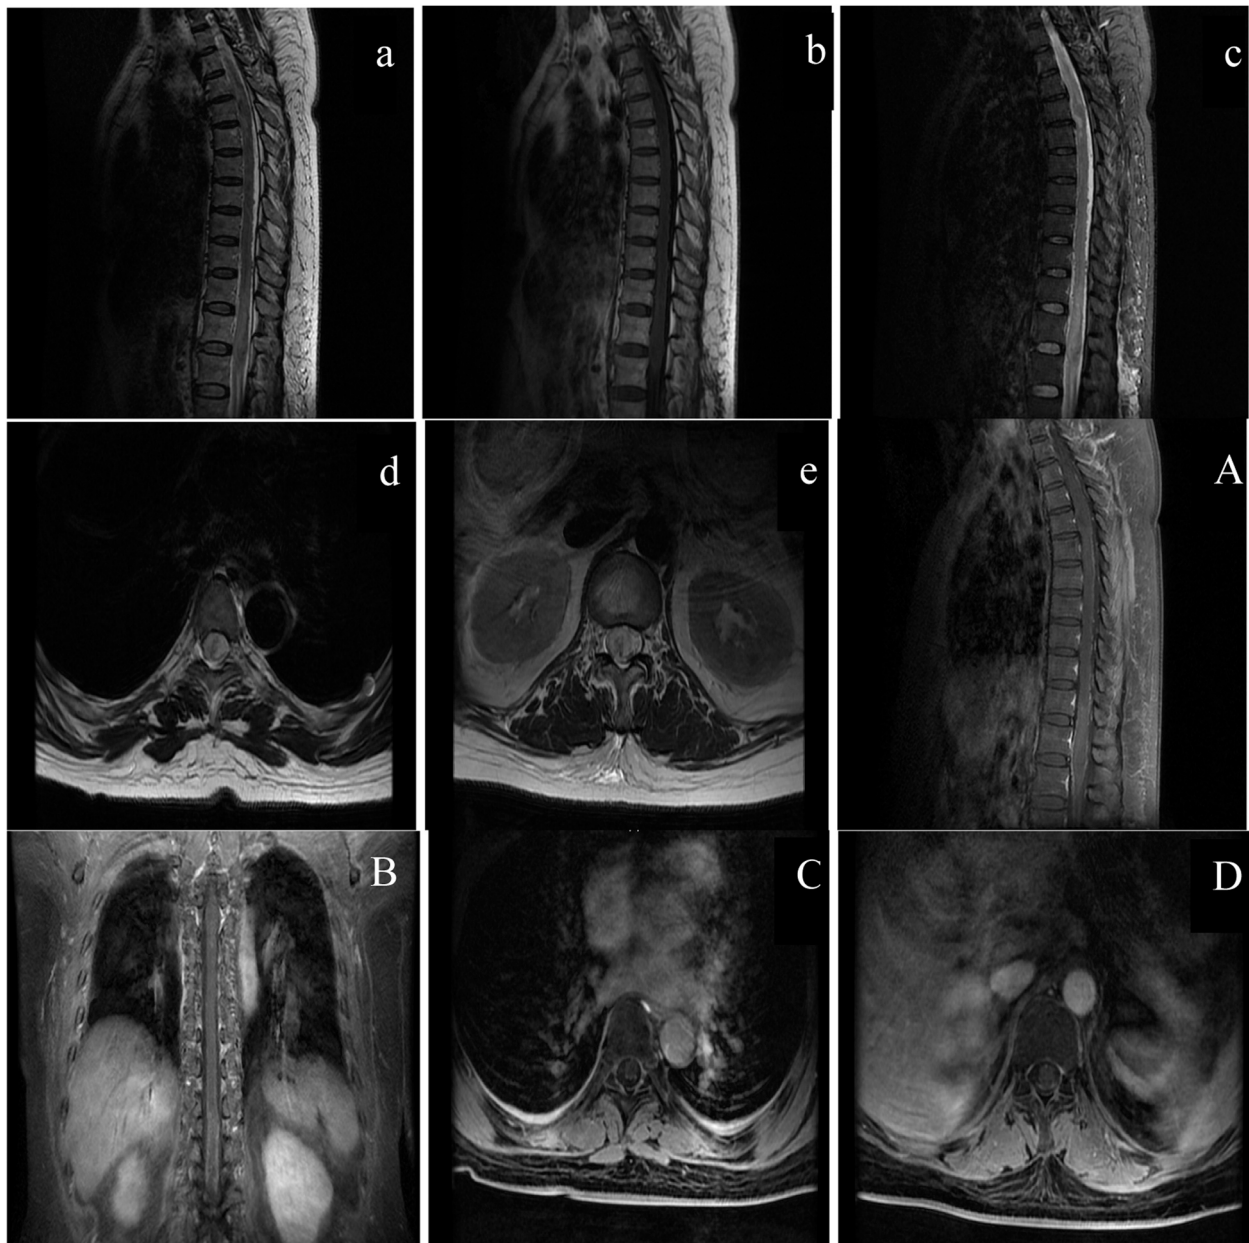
Magnetic resonance imaging (MRI) findings. Sagittal T2-weighted (WI) image (a), sagittal T1WI image (b), sagittal fat-suppressed image T2WI image (c), and axial T2WI images (d, e). The spinal cord showed irregular thickening, heterogeneous signals, multiple patchy long T1 and T2 signal intensities, and hyperintensities on fat-suppressed imaging. Contrast-enhanced MRI findings in the sagittal (A), coronal (B), and axial (C, D) planes. The spinal cord showed multiple patchy enhancements, particularly in the lower half.
